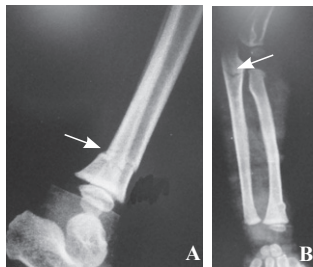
Left limb bone X-ray showing fractures in the left proximal and distal radius (A) and the distal fibula and tibia (B).
